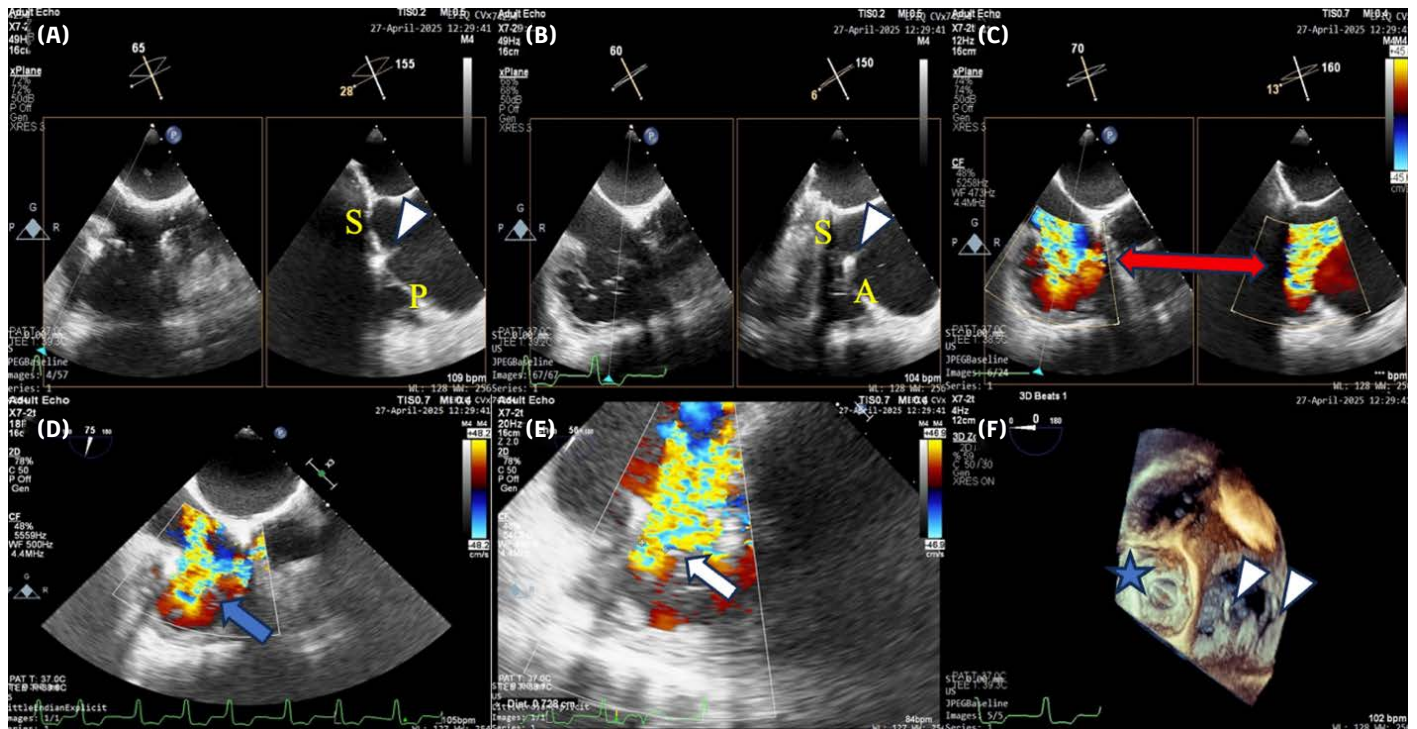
Intraprocedural and post-procedural transesophageal echocardiography (TEE) images: (A) X-plane view in the mid-esophageal right ventricular inflow-outflow window showing successful grasping of the septal (S) and posterior (P) leaflets of the tricuspid valve with a clip (white arrowhead); (B) X-plane view demonstrating grasping of the septal (S) and anterior (A) leaflets with a clip (white arrowhead); (C) Pre-procedural color Doppler imaging in the same view showing torrential tricuspid regurgitation (red arrow), with a vena contracta (VC) $\geq$ 21 mm; (D) Post-deployment of the first clip between the posterior and septal leaflets, a reduction in the regurgitant jet is observed (blue arrow, VC: 11 mm); (E) Following placement of a second clip between the prior clip and the septal-posterior leaflets, a further decrease in vena contracta is evident on color Doppler (white arrow, VC: 7 mm); (F) 3D TEE image showing the mechanical mitral valve replacement (MVR) (blue star) and implanted clips (white arrowheads).
